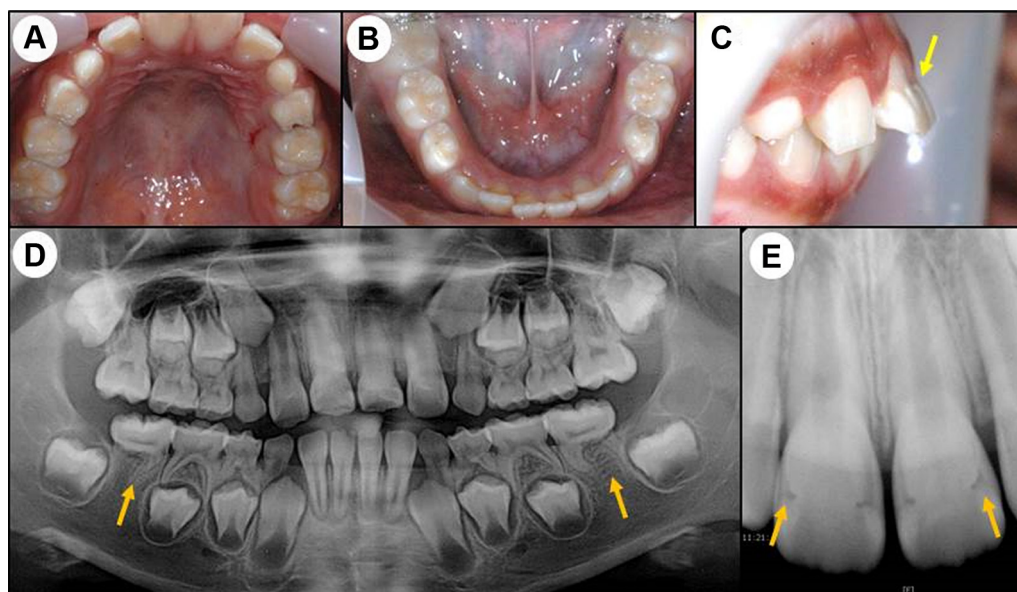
Case 1 (patient 1). Clinical photographs and radiographic films. A, Clinical intraoral photograph (maxilla) of a girl aged 7 years and 8 months obtained 9 months after the first visit, showing a normal crown contour and alignment. B, Clinical intraoral photograph (mandible) obtained at the same time as A, showing normal crown form and alignment. C, Clinical intraoral photograph (lateral) obtained at the same time as A, showing wedge-shaped defects on the labial surface of the upper incisors (yellow arrow). D, In the panoramic film obtained on the first visit, both lower first permanent molars exhibit a normal crown contour, but the distal roots are vestigial or undeveloped (yellow arrows). In addition, the pulp cavities in the crowns seem to be constricted into a straight form. E, In the periapical film obtained at the same time as D, the cervical one-third to one-half of the crowns exhibits a wedge-shaped defect (yellow arrows).
